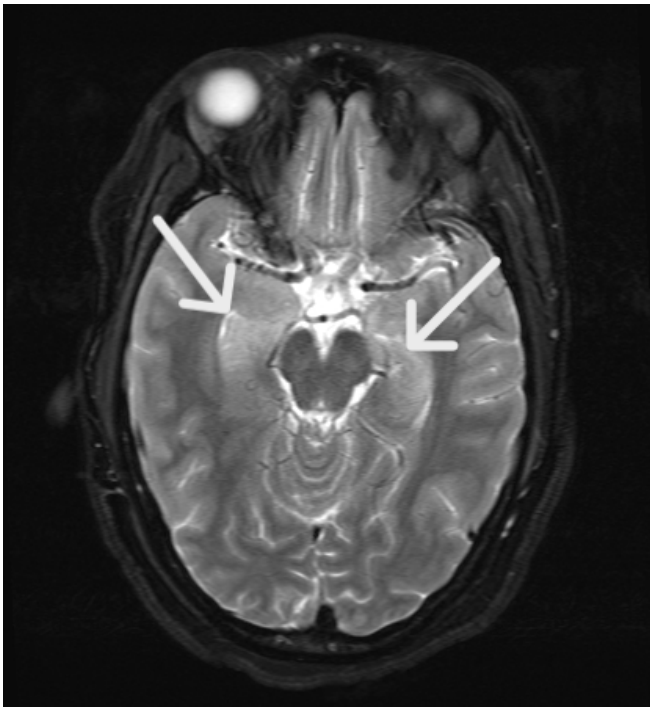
Axial brain MRI showing hyperintense T2-FLAIR signal within the bilateral hippocampi (white arrows), left greater than right.
